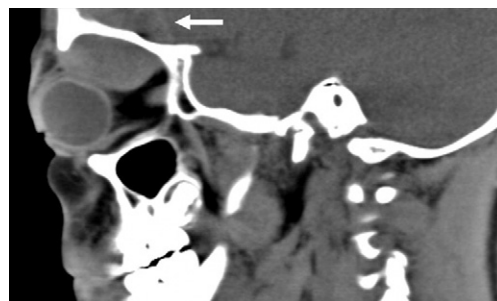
Sagittal computed tomographic image. Used with permission of Mark I. Neuman, MD, MPH, the Division of Emergency Medicine, Children's Hospital and Harvard Medical School, Boston, MA.
